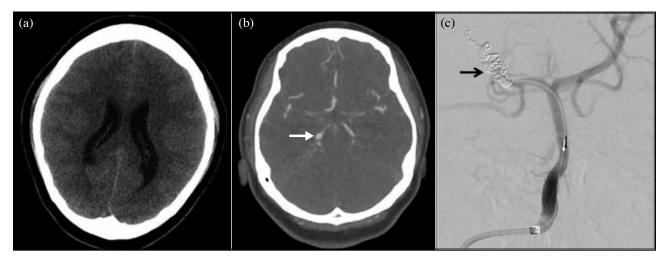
Patient 1: (a) A computed tomography scan showing diffuse subarachnoid haemorrhage with bilateral sulcal spaces effaced. (b) A computed tomography angiogram showing a cerebral aneurysm (arrow) arising from the right posterior cerebral artery. (c) A digital subtraction angiogram showing endovascular coiling (arrow) of an intracranial vessel
